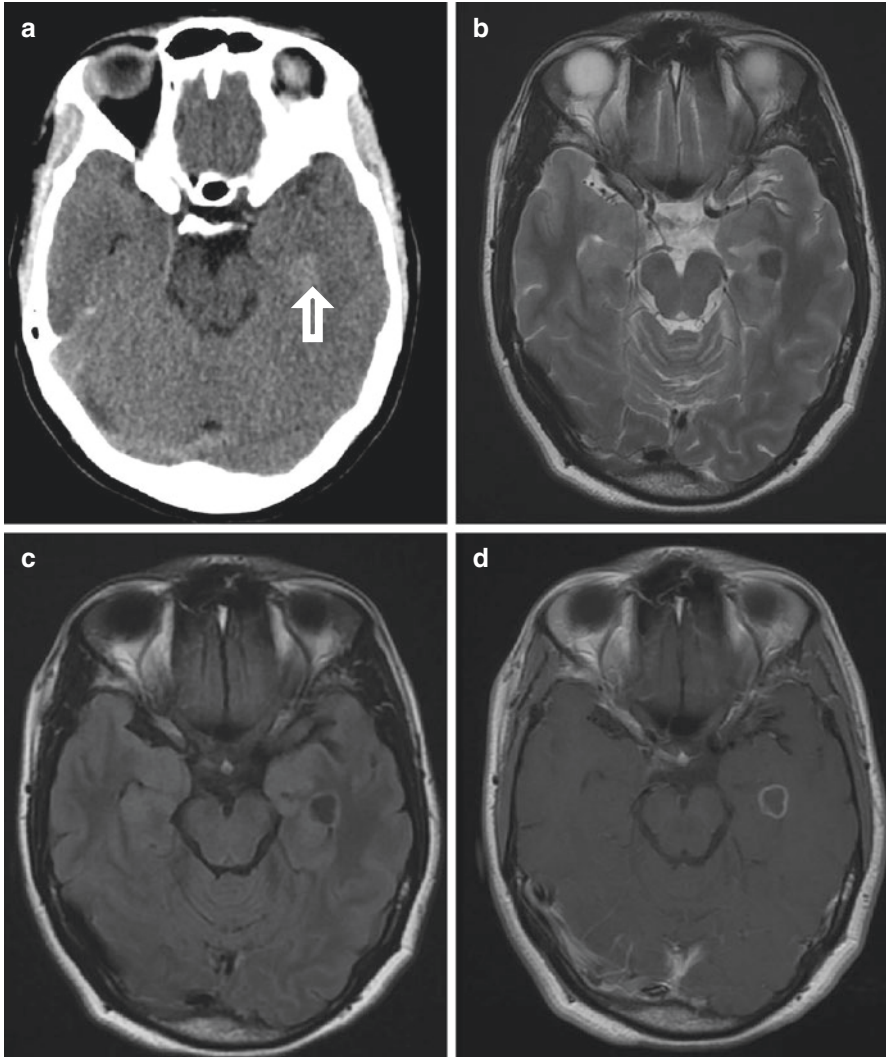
Tuberculoma. There is a focal lesion in the left temporal lobe which is hyperdense on CT (a, arrow), hypointense on T2 (b) and FLAIR (c) weighted MR images, and demonstrates peripheral contrast enhancement on the post-contrast axial T1 weighted image (d). Note the surrounding oedema seen on the T2-weighted image (b)
